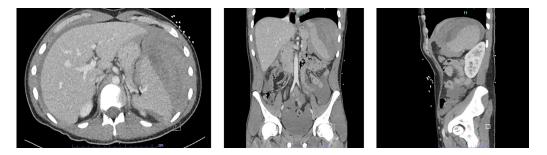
Axial, coronal and sagittal CT imaging showing AAST grade III splenic injury with a large subcapsular and perisplenic haematoma.
